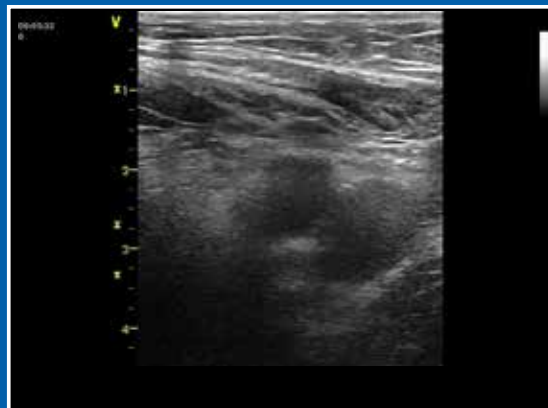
Femoral Artery and Vein Anatomy Using Ultrasound (video)
